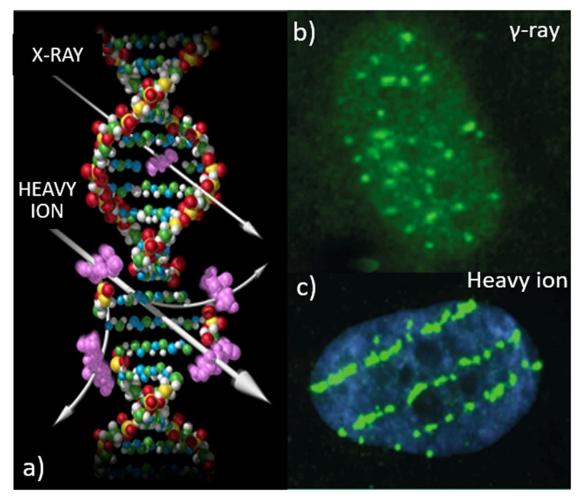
(a) High (H) charge (Z) and energy (E) ions, often referred to as HZE ions, produce dense ionization along the particle track as they traverse a tissue and impart distinct patterns of DNA damage compared to terrestrial radiation such as X-rays or gamma radiation.  $\gamma$ H2AX foci (green) illuminate distinct patterns of DNA double-strand breaks in nuclei of human fibroblast cells after exposure to (b) gamma-rays, with diffuse damage, and (c) HZE ions with single tracks. Image credits: (a) NASA and (b and c) Cucinotta and Durante [1].
